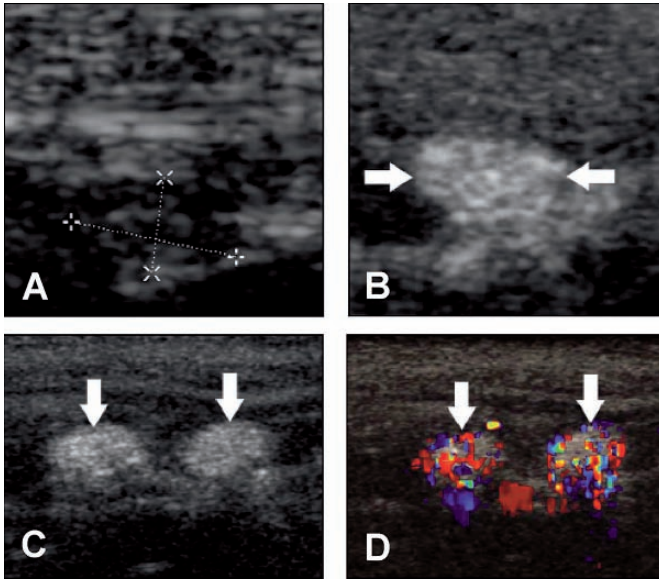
Different imaging modes are used to reveal a complete picture of sentinel lymph node location and anatomy. A Before contrast injection, grayscale mode shows the location of a lymph node and surrounding structures. B After contrast injection, contrast-specific grayscale mode demonstrates enhancement of this lymph node (right). C The enhancement demonstrated by two small sentinel lymph nodes in contrast-specific grayscale mode is confirmed in color flow mode (D) which shows contrast agent location with high sensitivity (Goldberg et al., 2005). Reprinted with permission from Goldberg et al., 2005. Contrast-enhanced sonographic imaging of lymphatic channels and sentinel lymph nodes. *J Ultrasound Med* 24, 953–965.
